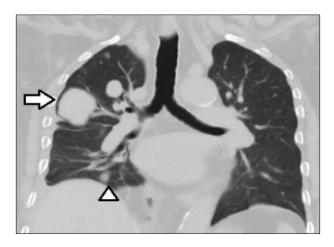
Coronal sections through the CT scan in lung windows with pulomnary metastasis.
